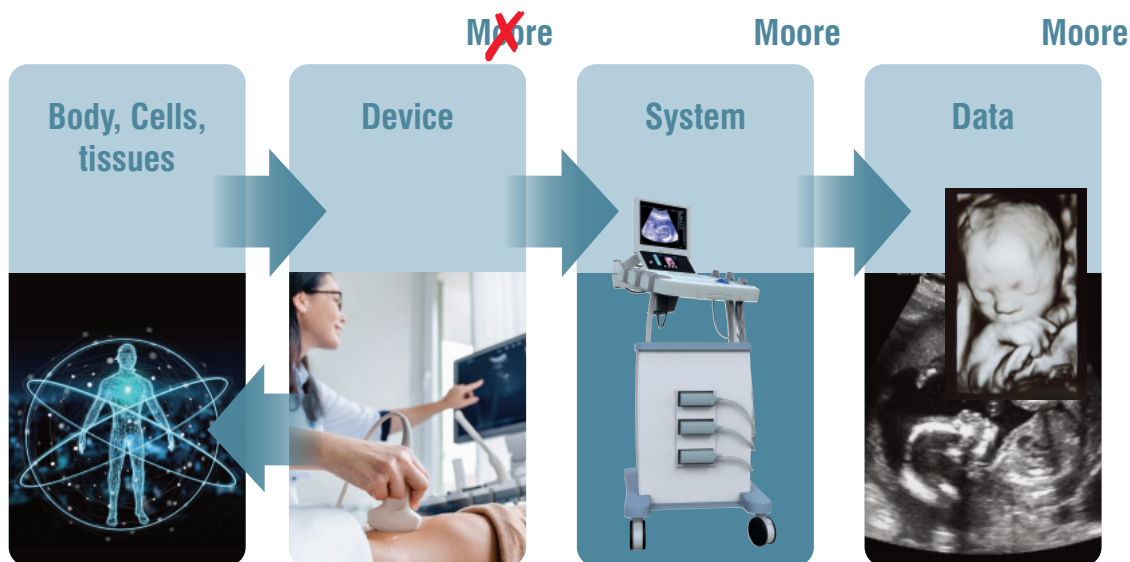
Traditional diagnostic ultrasound is a typical example of a medical device where innovation speed is limited by innovation at the device level.
